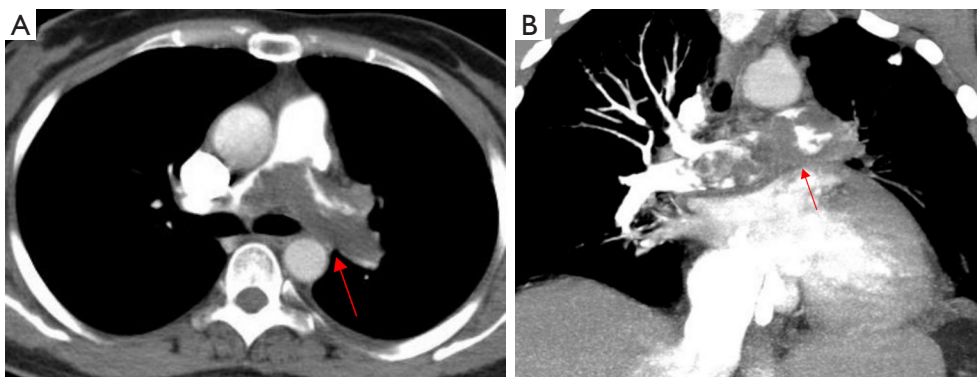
Computed tomography pulmonary angiography shows filling defects in the right and left pulmonary arteries, spreading to the outer lumen (red arrows) (A,B).
